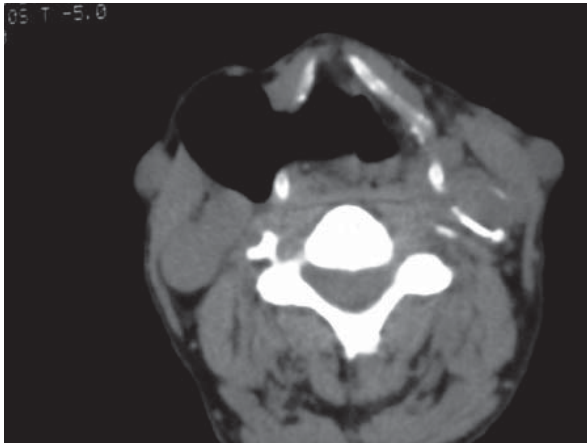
Computed tomography image of patient's neck: extended gaseous right laryngocele located on soft parts of neck.
